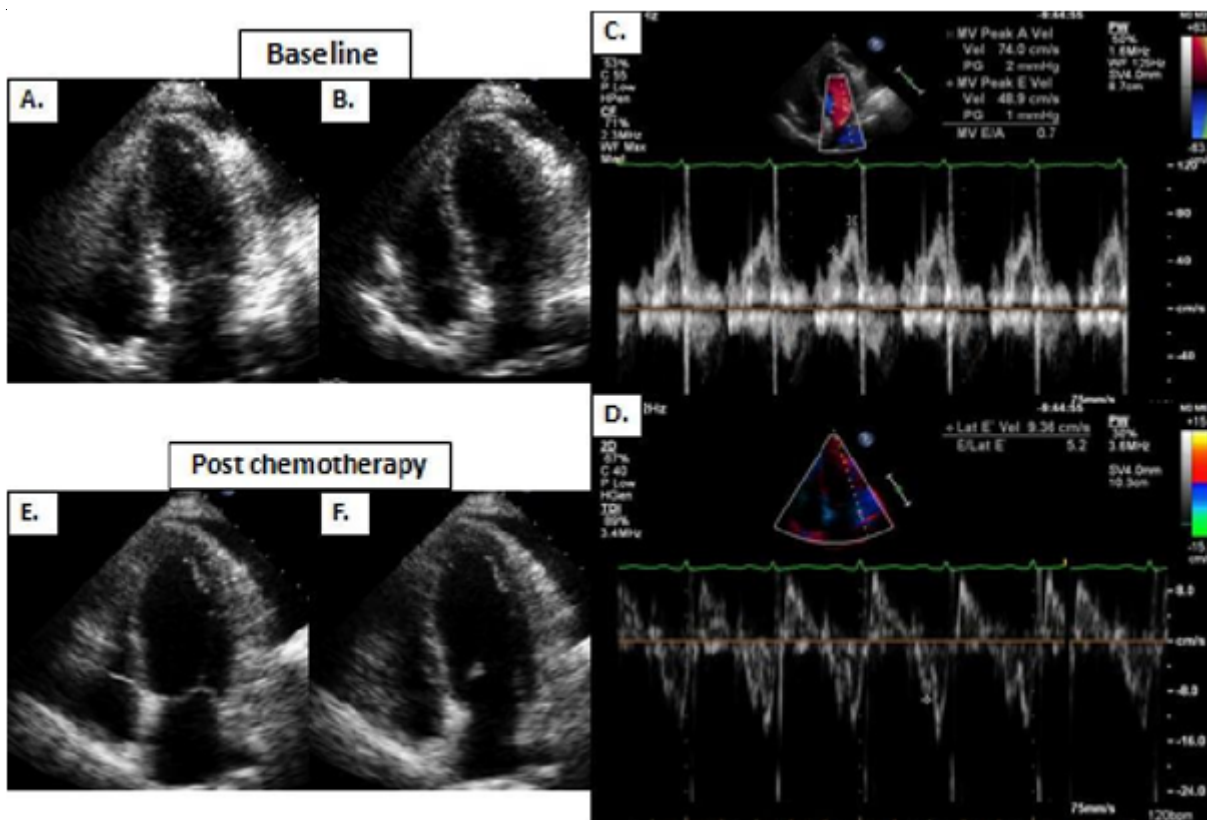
A 52-year-old woman diagnosed with breast cancer receiving anthracyclines. Baseline 4 chamber view of 2D-echocardiogram in end systole and end diastole. A and B: Normal LVEF (LVEF = 50%, LVEDV = 47 ml, LVESV = 25 ml). C and D: Baseline mitral inflow to annular ratio (E/e')—obtained using routine pulsed-Doppler of the mitral inflow and pulsed-tissue Doppler of the lateral mitral annulus—demonstrated mild diastolic dysfunction, impaired relaxation of the left ventricle (mitral peak A velocity = 74 cm/s, mitral peak E velocity = 48.9 cm/s, mitral E/A = 0.7, E/e' = 5.2). Postchemotherapy 4 chamber view of 2D-echocardiogram in end systole and end diastole. E and F: A reduced LVEF (LVEF = 29%, LVEDV = 62 ml, LVESV = 44 ml). Mitral inflow and TDI were uninterpretable because of arrhythmias causing fusion of the E and A waveforms. E: peak early filling velocity, A: velocity at atrial contraction, e': velocity of mitral annulus early diastolic motion, TDI: tissue Doppler imaging.
